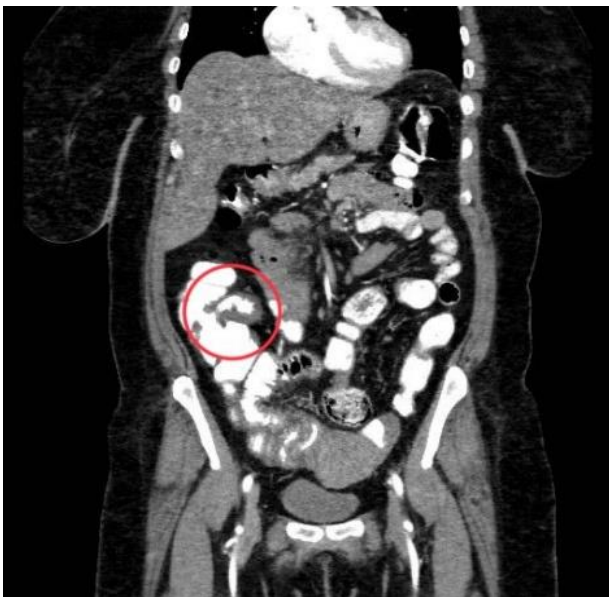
Coronal computed tomography scan of ileum with intravenous and oral contrast demonstrating the presence of pedunculated intraluminal soft tissue lesion with a fat component at the distal ileum and intestinal wall thickening.
